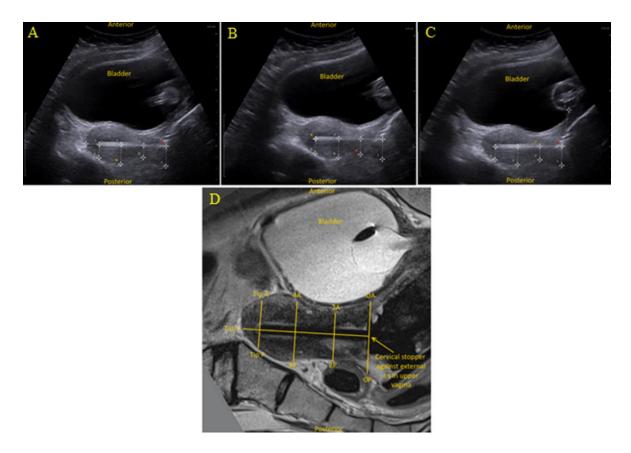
Nomenclature for measurement points on longitudinal ultrasound views
